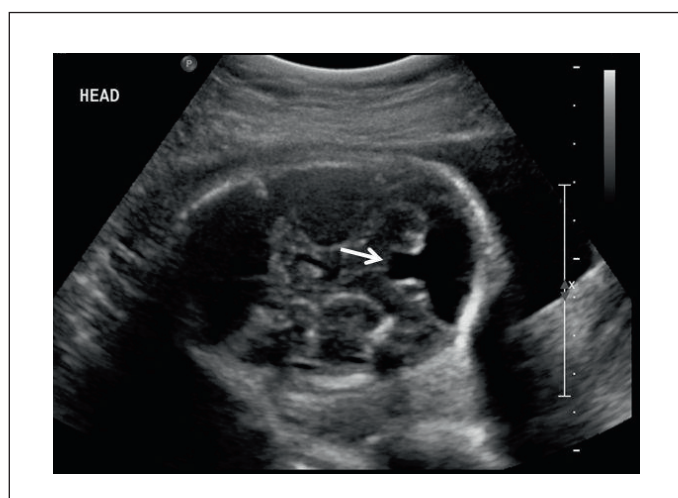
Ultrasound at 22 weeks demonstrates hypoplasia of the cerebellar vermis and dilation of the cisterna magna.
